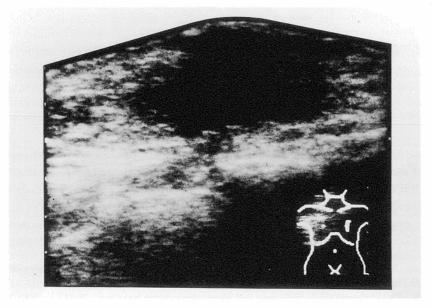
An irregular heterogeneous hypoechoic mass was revealed by an ultrasonogram.
